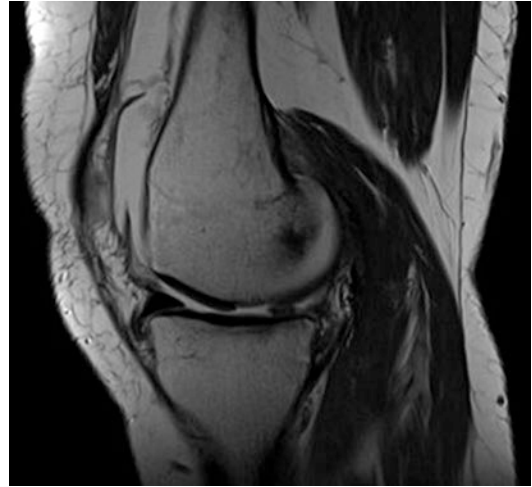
Sagittal MRI with the absence of the posterior horn of the medial meniscus, demonstrating a ghost sign indicative of a radial tear
